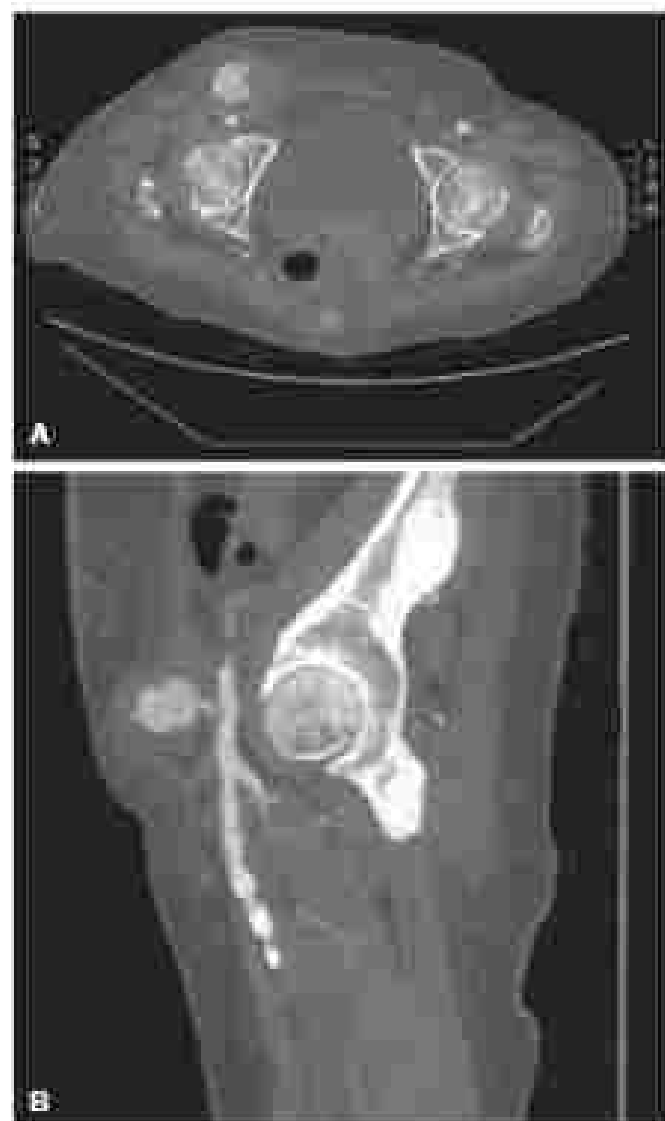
Computed tomography angiographic axial (A) and sagittal (B) images of a right iliofemoral pseudoaneurysm and neck.
